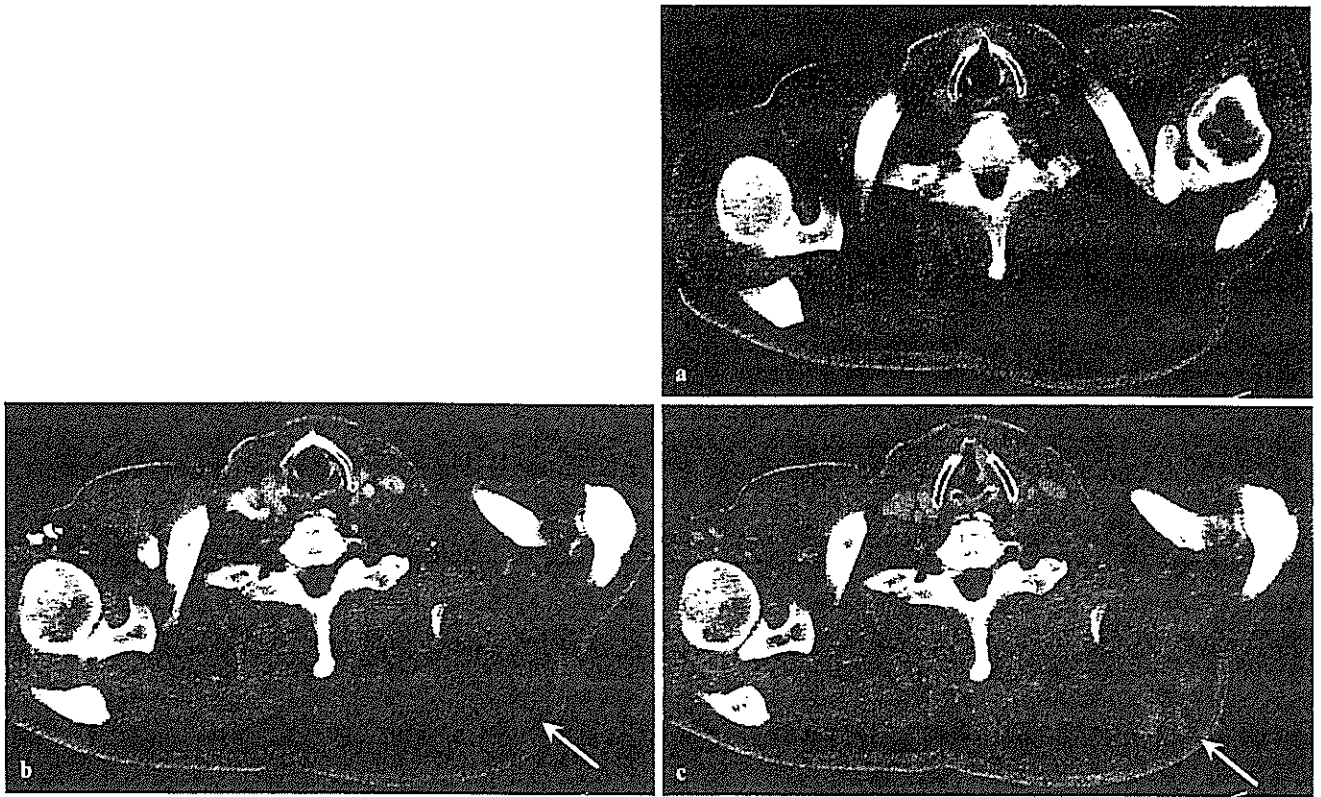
a Precontrast axial computed tomography (CT) image shows a hypodense fatty tumor interspersed within isodense areas in the back. b On the arterial phase of a post-contrast-enhanced CT image (30s after injection), nonadipose areas are enhanced
